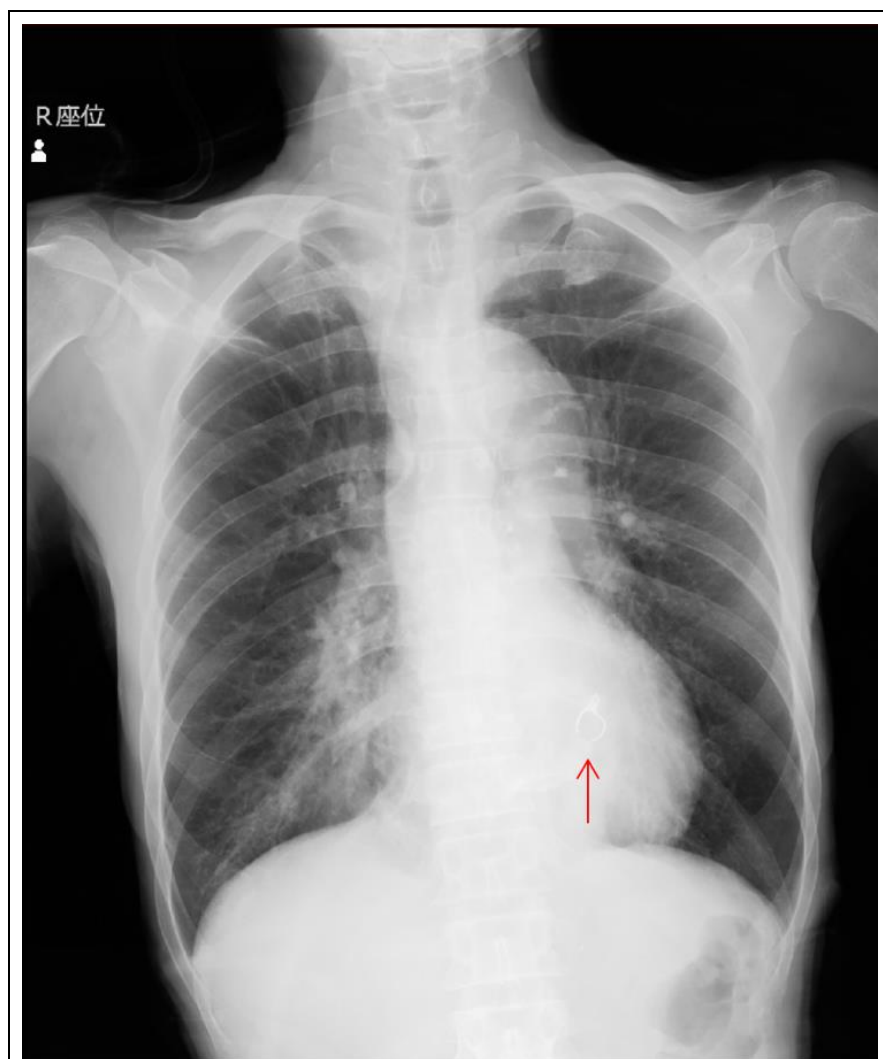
Chest X-ray suggests a foreign body (red arrow) on the mediastinal side of the left lower lung field.
